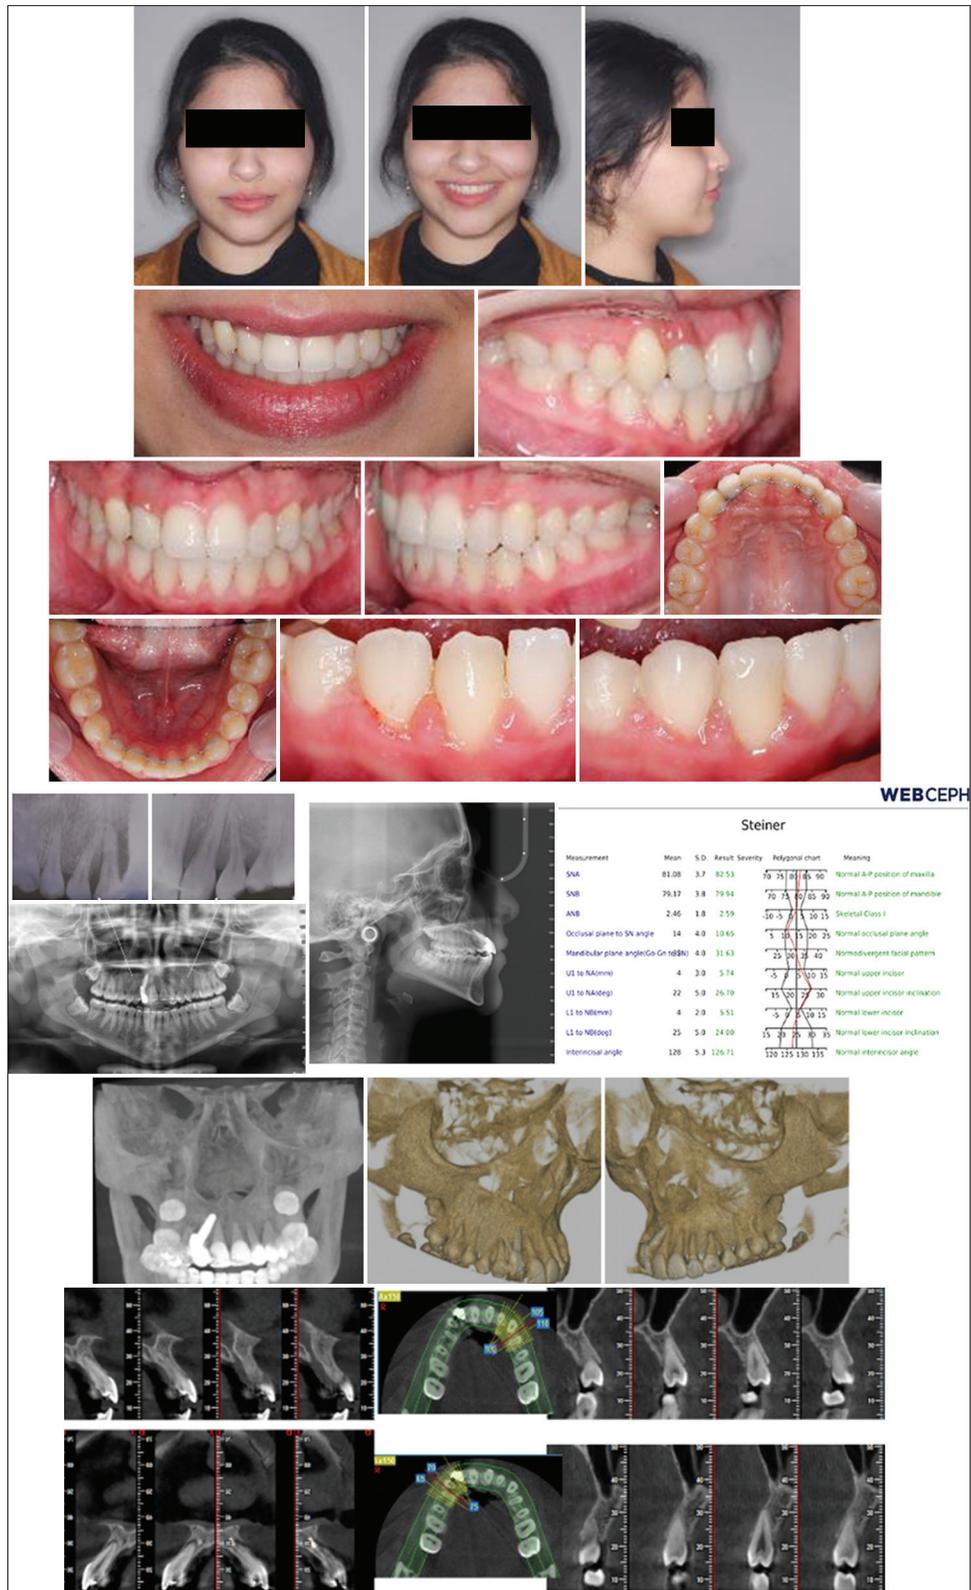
Final clinical aspect after orthopedic treatment including extra and intraoral pictures with preapical, cephalometric (include tracing), and cone-beam computed tomography radiograph
